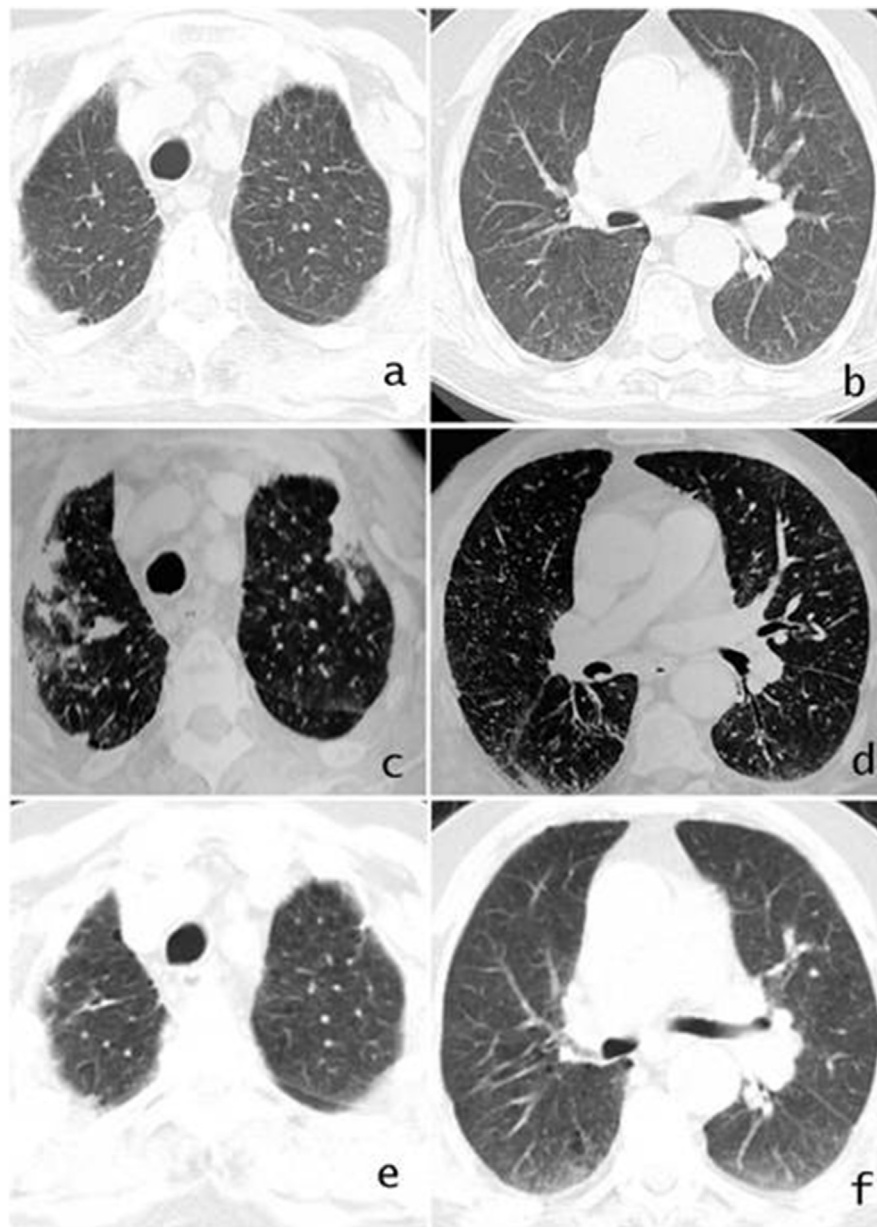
Chest CT showing fibrous tissue in both apices at the beginning (a,b), miliary tuberculosis and opacities in both upper lobes (c,d) and significant improvement after anti-TB treatment (e,f).
